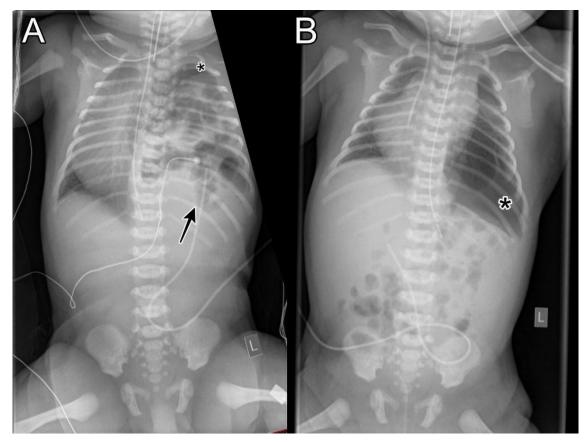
Chest and abdominal radiography. Figure 3A, taken on the first day of life (preoperatively), shows left CDH with abdominal content in the thoracic cavity (arrow) and subtotal compressed left lung (asterisk) with mediastinal compression and deviation to the right side. Figure 3B, taken after surgery, shows successful repositioning of the abdominal organs in the abdominal cavity, a pneumothorax and effusion (asterisk), and a slight ingredient mediastinal deviation.
